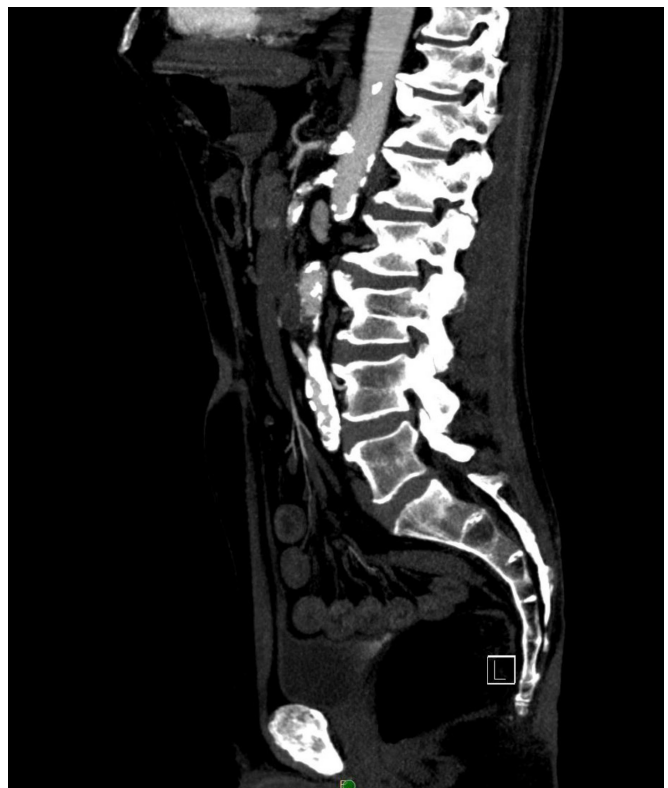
Computed tomography angiography demonstrating occlusion of the celiac artery with a high-grade severe stenosis of the calcified superior mesenteric artery
